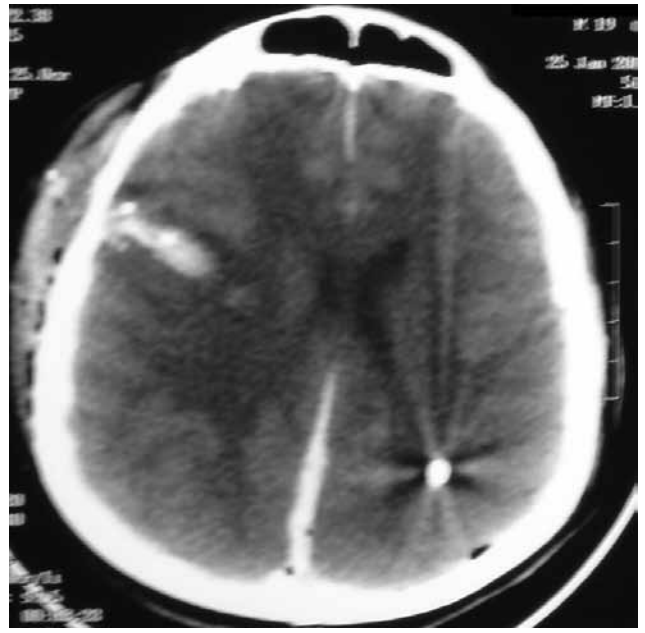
CT scan showing an intracerebral hemorrhage under the fracture and the metallic body.
